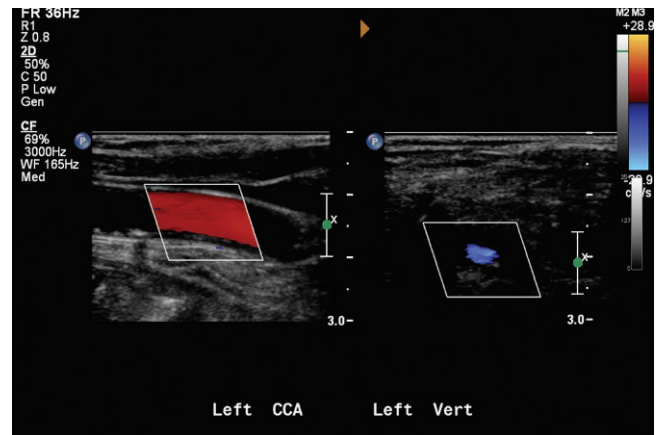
The vertebral artery color Doppler is blue, in opposite direction than the red common carotid artery. The vertebral artery flow is toward the feet.
